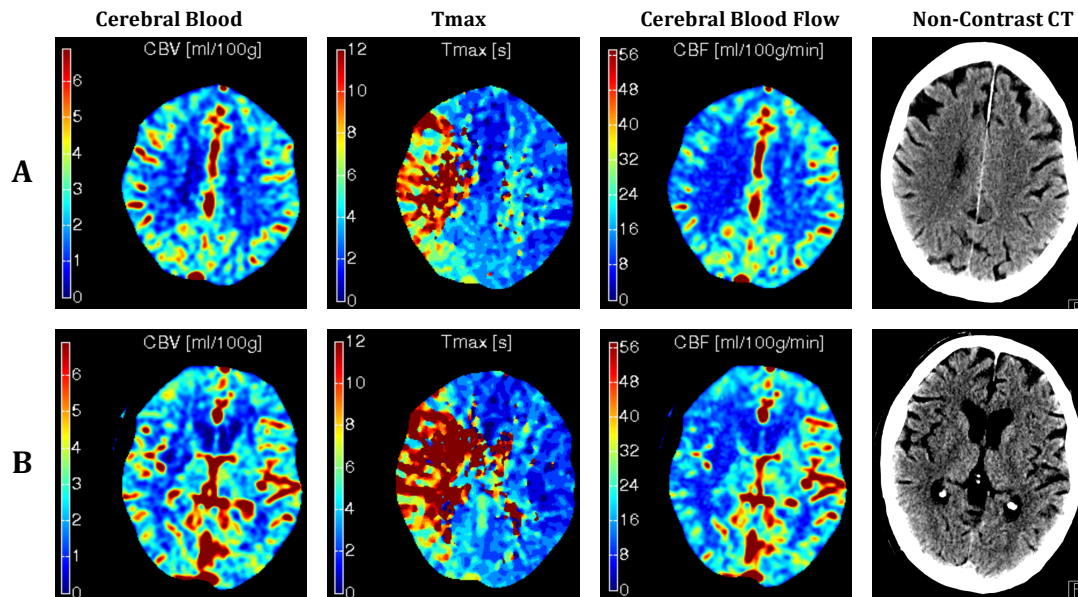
Example of ASPECTS scoring on CT Perfusion
